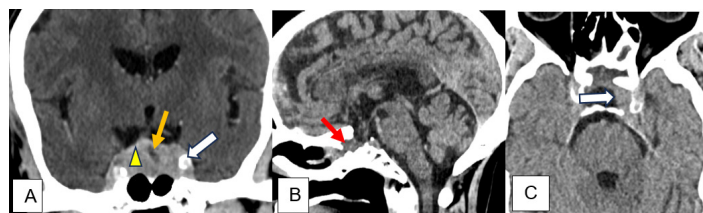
CT scan of the skull with injection. The coronal section shows in A a tissue process widening the sella turcica (yellow triangle) and invasion of the left cavernous sinus with a discrete mass effect on the temporal lobe opposite (white arrow in 1A). We also note a lacuna in the macroadenoma (thin arrow). The subsellar changes reflect the transsphenoidal pathway (arrow 1B) with a tumor residue visible on the left (arrow 1C).
